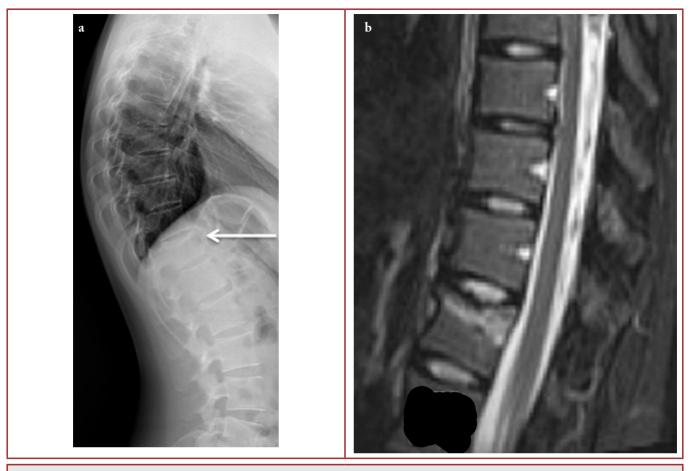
17 year-old girl. a) White arrow shows T12 compression fracture. b) T2-weighted sagittal MRI shows T12 bone edema and compression fracture.
